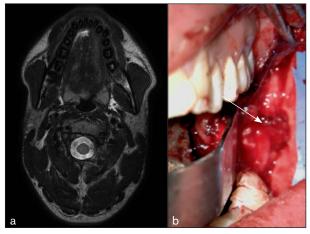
(a) MRI and (b) surgical images of a patient reporting trigeminal pain after third molar extraction. The treating physician suspected PTNP of the lingual nerve, and an MRI (T2-weighted sequence) was performed. There were no artifacts that limited the reporting of a possible lesion, but the lingual nerve could not be visualized on the MRI. During surgery, complete transection of the lingual nerve was found (arrow).
